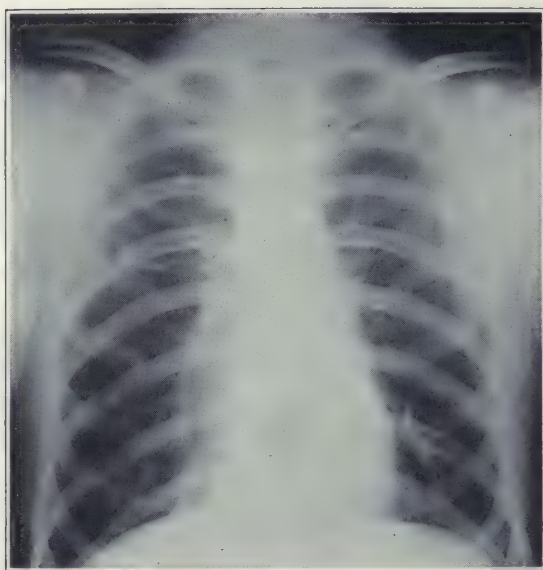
Same case as in Figure 12 after eight months' roentgen-ray treatment.
